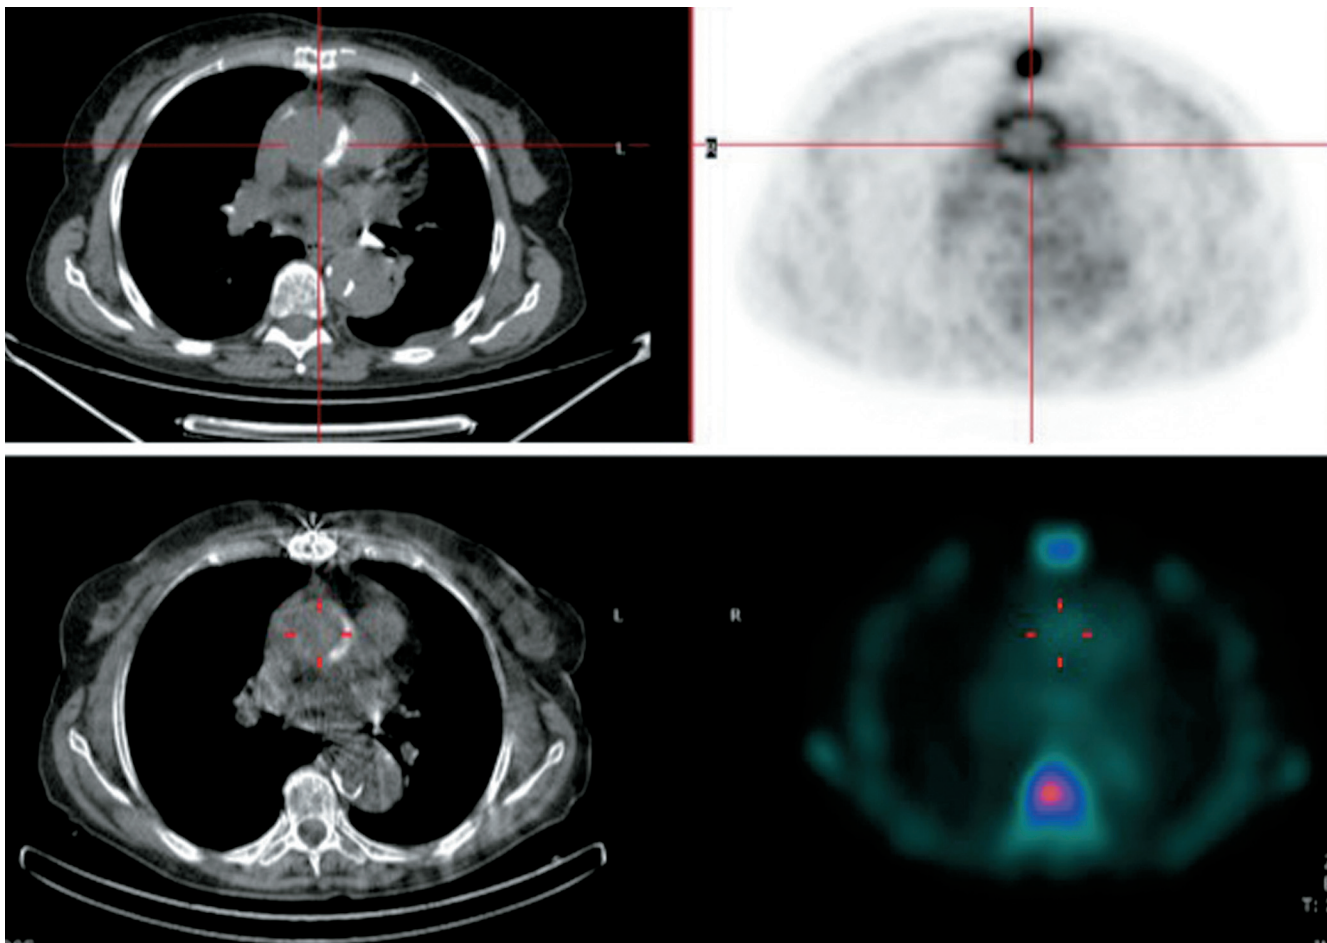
Upper images: [^{18}F]FDG PET/CT in a patient referred for fever of unknown origin. Images show a diffuse uptake of FDG both in the aortic wall and in the recent sternotomy. Lower images: [$^{99\text{m}}\text{Tc}$]-HMPAO labelled WBC with SPECT/CT acquisition at 20 h post injection in the same patient, showing no uptake in the aortic valve and moderate, physiological uptake in the sternotomy (false positive of [^{18}F]FDG PET/CT).
